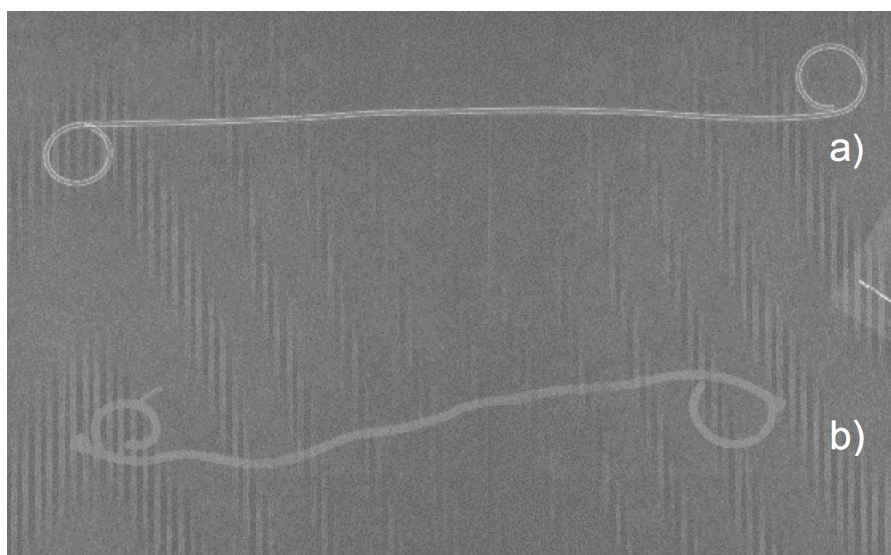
2 Radiograph in abdomen mode of a) commercial ureteral stent (Biosoft® duo, Porges, Coloplast) and b) biodegradable ureteral stent developed (formulation 2, 0.48M).
